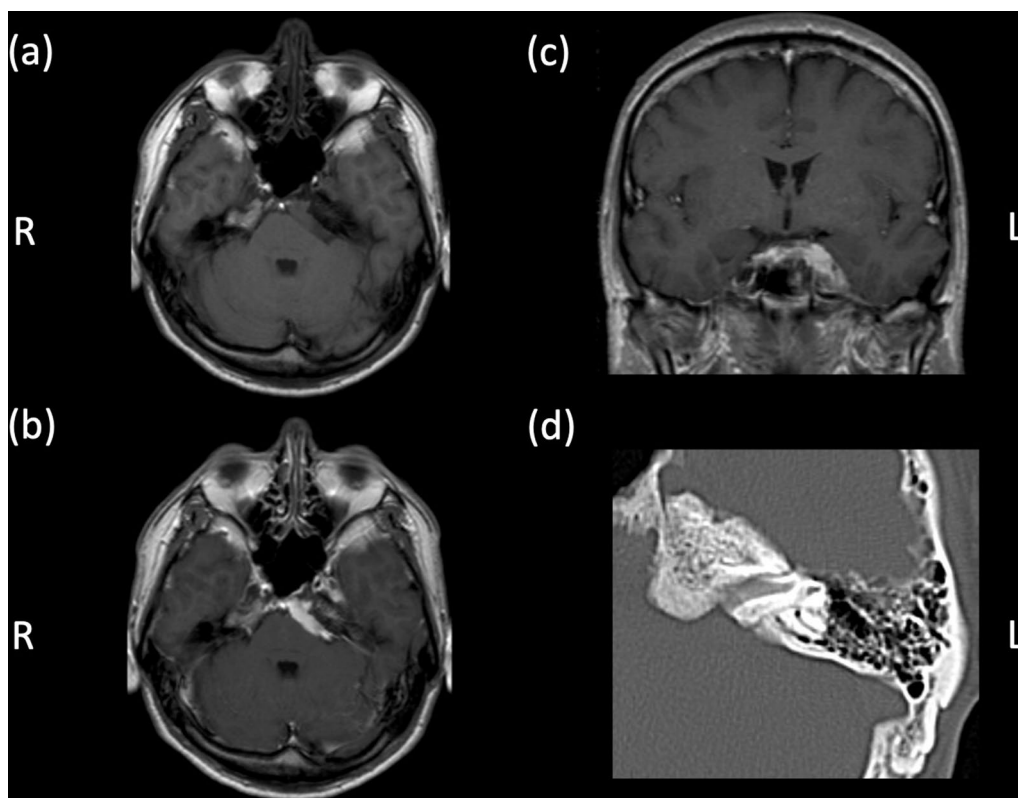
Preoperative images of the cavernous sinus tumor. a Axial view of T1-weighted image on brain MRI. b Axial view of gadolinium-enhanced T1-weighted brain MRI demonstrating a well-enhanced tumor and enhanced petrous bone. c Coronal view of the gadolinium-enhanced T1-weighted MRI. d Axial image of CT demonstrates petrous bone thickening and stenosis of internal auditory canal
